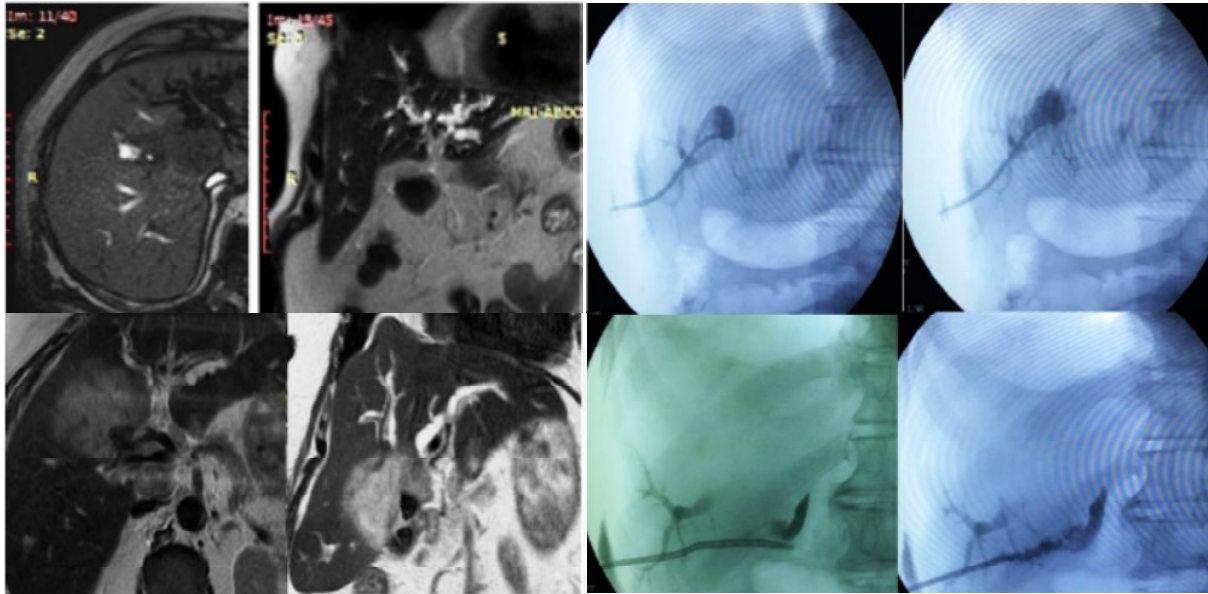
MRI, PTC and PTCB
